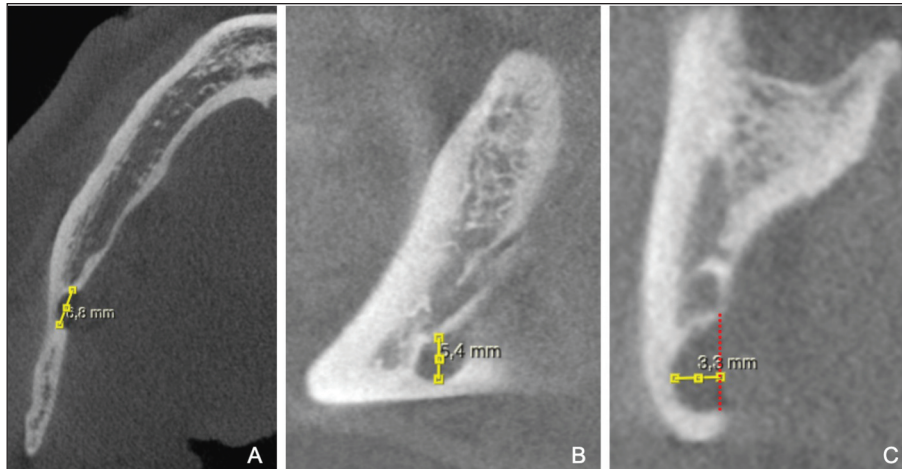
Determination of lesion dimensions in 3 orthogonal planes on cone-beam computed tomography images. A. Measuring the width of the lesion on the axial section, B. Measuring the height of the lesion on the sagittal section, C. Measuring the depth of the lesion on the coronal section.
